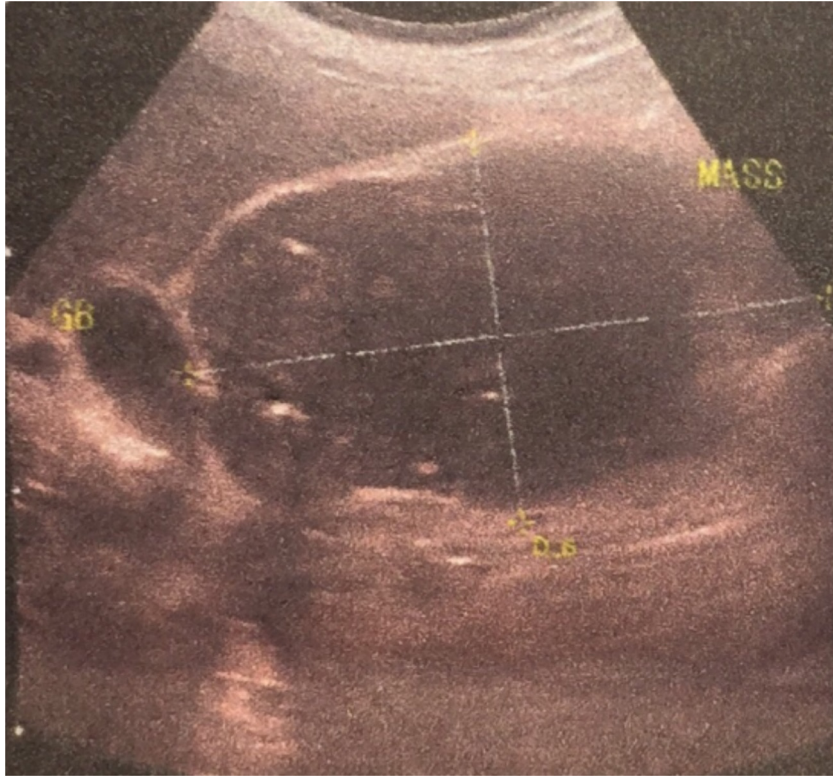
Ultrasound showing mass adjacent to gallbladder, arising from the liver.
